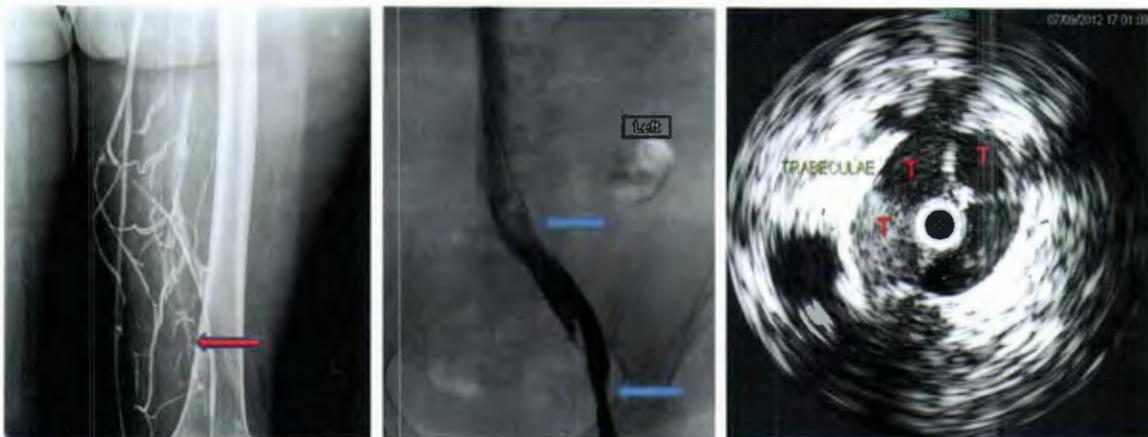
Post-thrombotic femoral vein occlusion (*left*) with suspected concurrent iliac vein lesions shown by *arrows* (*middle*). Extensive trabeculations (*T*) were seen in the external iliac vein on intravascular ultrasound (IVUS) examination, which was not suspected on the venogram. The IVUS catheter can be seen in the center (*right*).
